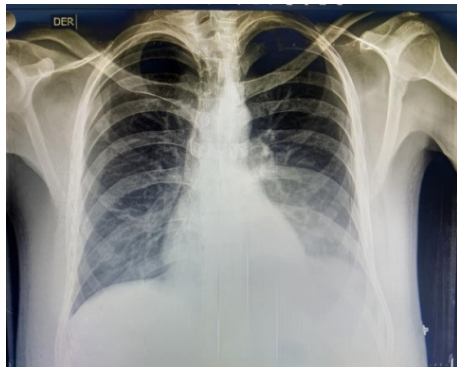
PA chest x-ray with visualization of the left cardio- and costophrenic angle, elevation of the hemidiaphragm
